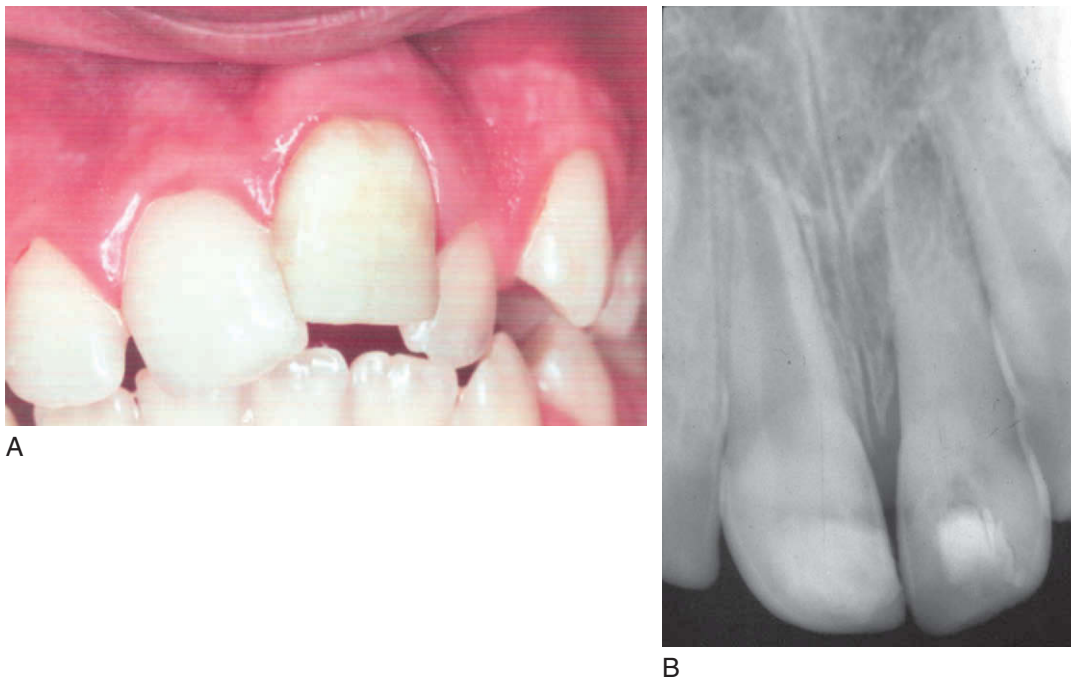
A, Avulsion with extended extraoral dry time occurred 8 months before the ankylosis of the maxillary right central incisor in this 10-year-old child, causing severe infraocclusion. There was extended extraoral dry time, so to maintain the volume of bone a decoronation procedure was performed. B, Radiograph showing arrested tooth development and ankylosis.
